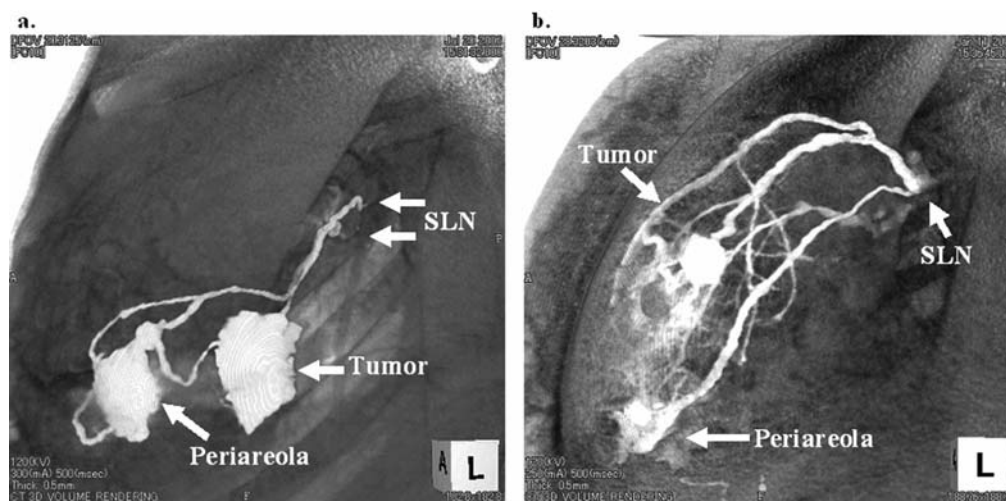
Visualization of SNs and lymph ducts (LD) using 3D-CT LG (13). Iopamidol was injected intracutaneously into the periareolar skin and the skin above the tumor. (a) Two LDs draining into two SNs. (b) Multiple LDs draining into a single SN.
